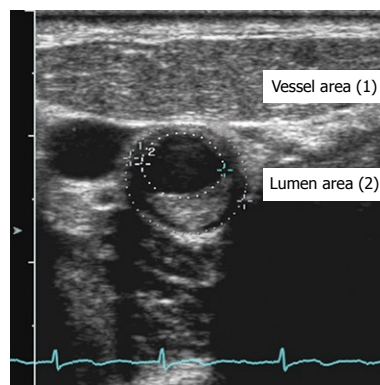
An example of carotid artery atherosclerosis seen with ultrasonography. Percent vessel area stenosis is plaque area (vessel area minus luminal area) divided by vessel area $\times 100$.
